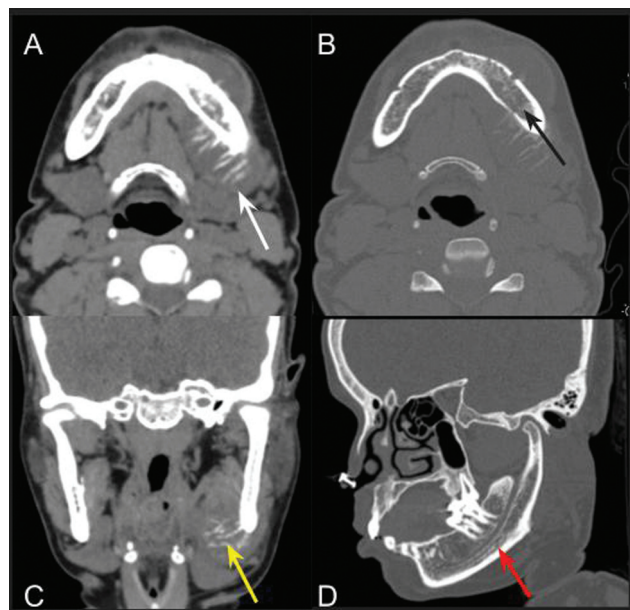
Osteomyelitis mimics in adults. Case of a 38-year old female with swelling over the left side of the neck around 2 months. Non-contrast computed tomography (NCCT) (A–D) shows hair on end and sunburst periosteal reaction (white arrow) with permeative lysis and cortical breach in the ramus and body of the left hemimandible (black arrow). Well-defined extraosseous soft tissue lesion in the submandibular region (yellow arrow) and left buccal space displacing submandibular gland posteroinferiorly with focal loss of fat planes. Also, there is widening and irregularity of the wall of the left inferior alveolar canal (IAC; red arrow). Final diagnosis was primary bone tumor—osteosarcoma.
